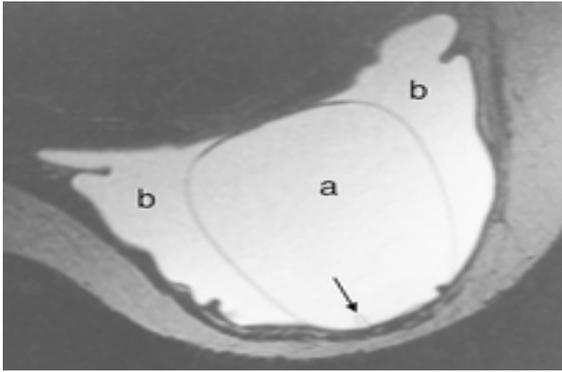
Axial T2-weighted fast spin-echo water-suppressed MR image of triple-lumen implant showing silicone gel in the inner (a) and middle (b) lumens of this triple-lumen implant. The saline is gone from the outer lumen of this implant. Note the usual buckled appearance (arrow) of the fold in the inner lumen shell anteriorly, adjacent to the middle lumen. This is not a sign of rupture (Middleton and McNamara, 2000).
